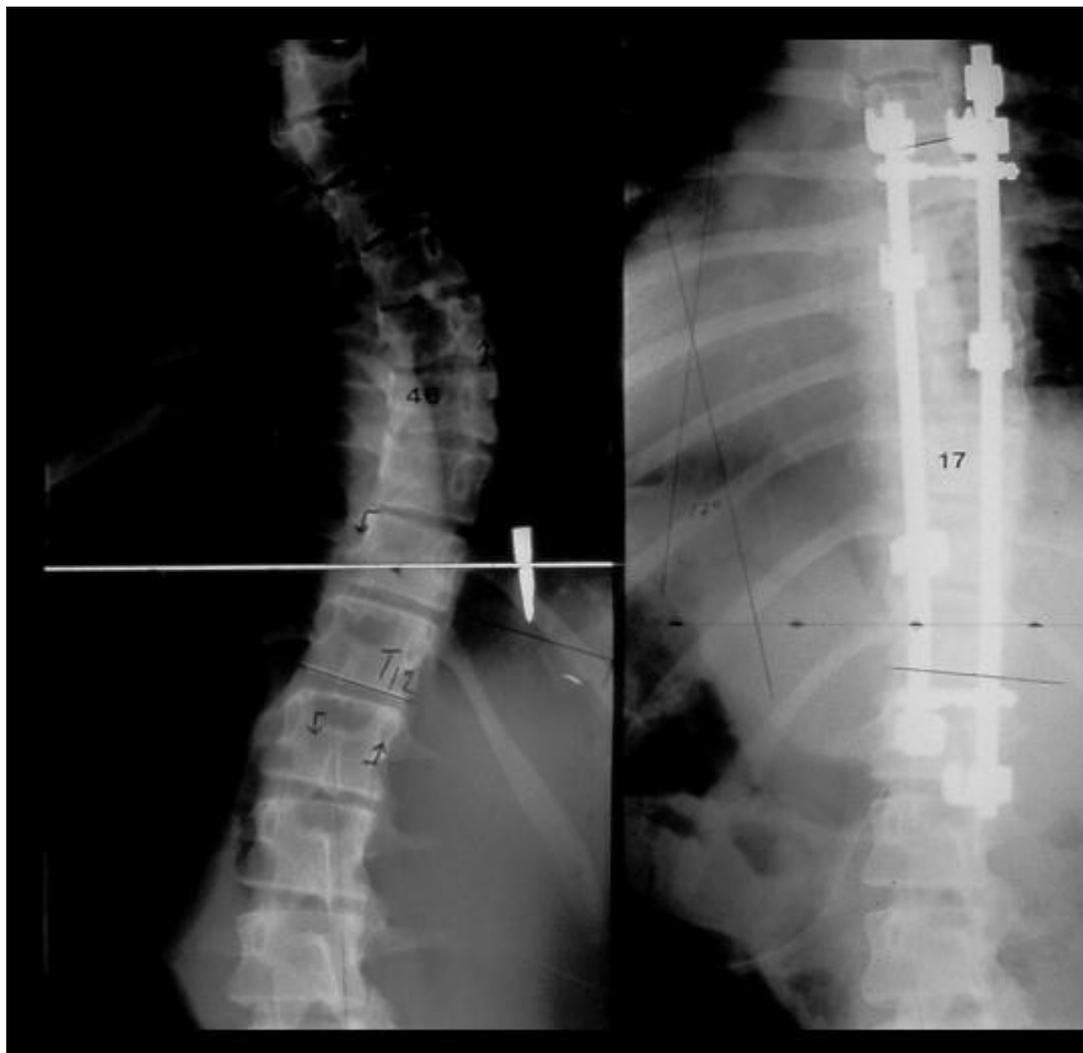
Radiographs that show idiopathic scoliosis in a girl aged 14 years before and after surgical treatment using Cotrel-Dubousset instrumentation.
